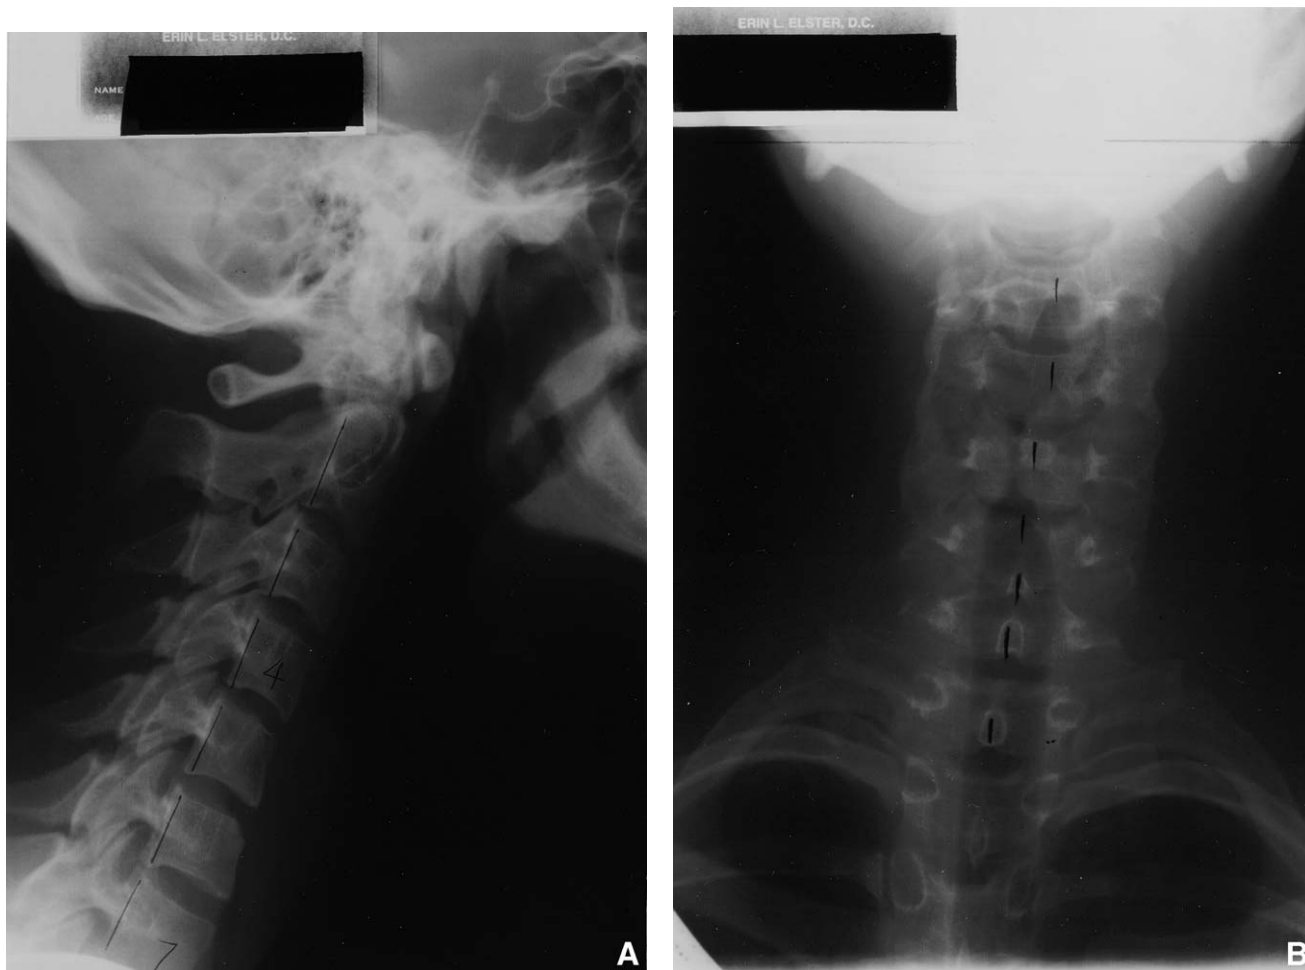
A through D, Upper cervical radiographs. Deviation of the upper cervical spine from the neural canal is present.*
